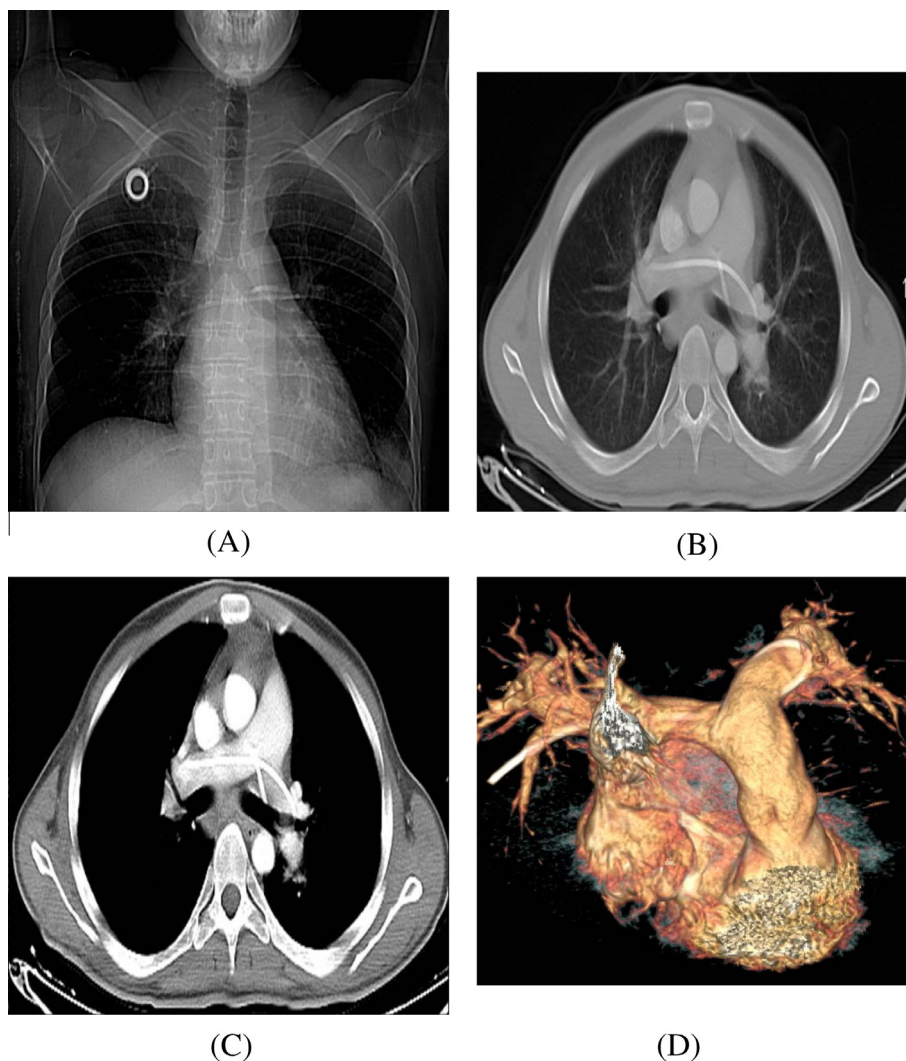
Chest radiography (A), CT chest in lung (B) and mediastinal (C) window settings with 3D reconstruction (D), showing the migrated catheter lodged in the pulmonary artery.
